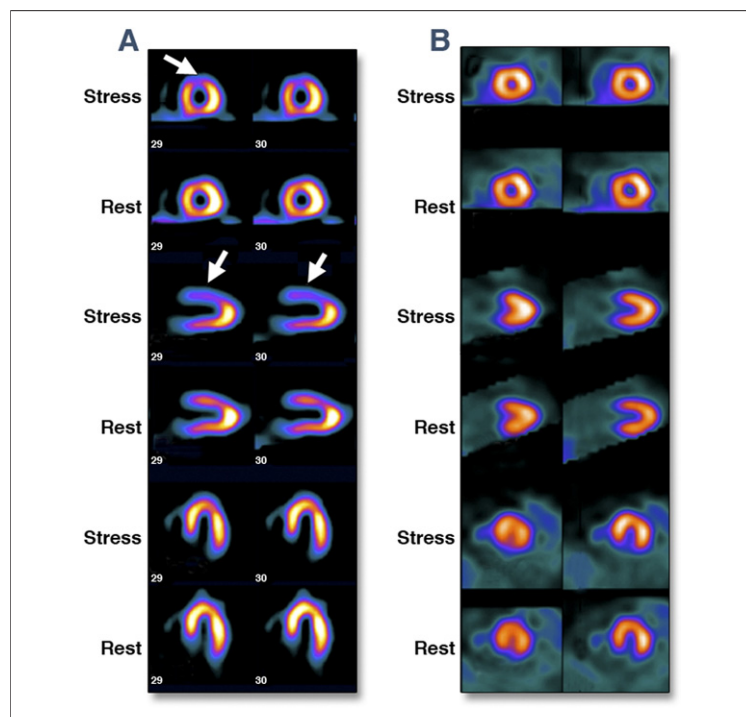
Examples of SPECT-MPI
